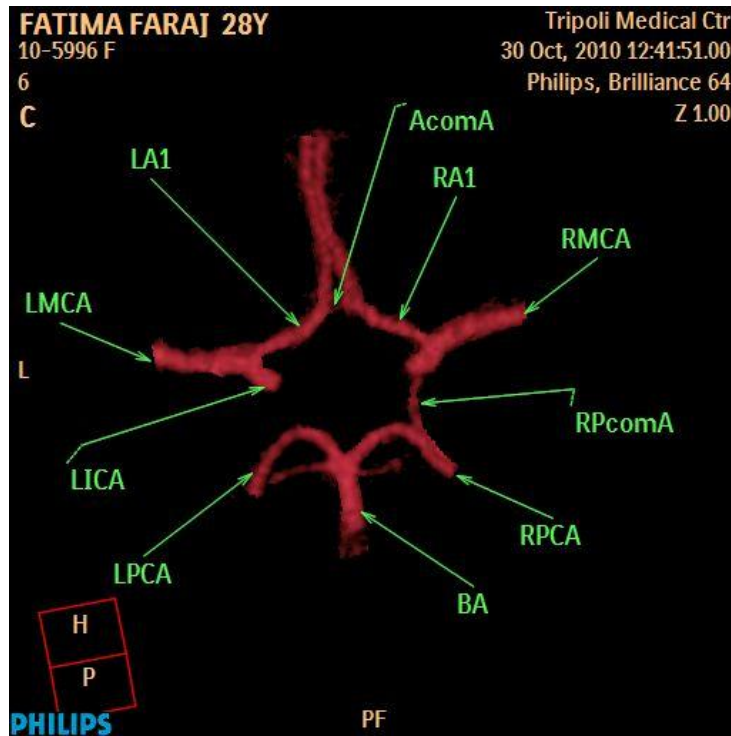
CTA shows missing LPcomA.
